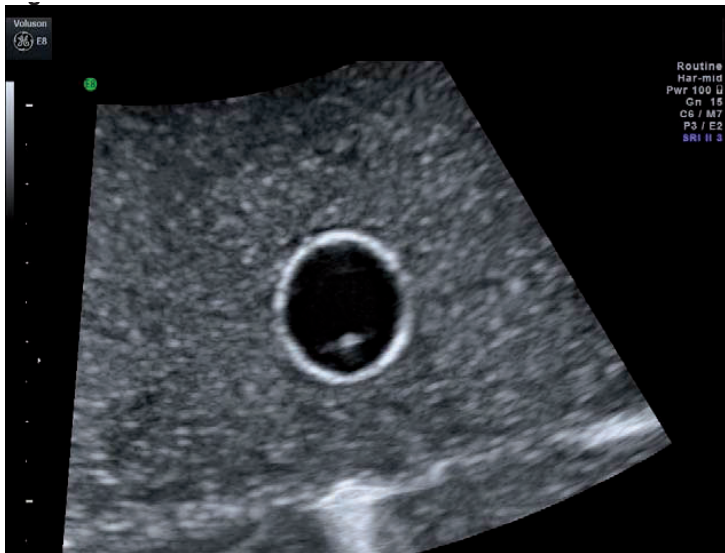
Image of a water balloon on the ultrasound machine (Voluson E8).
